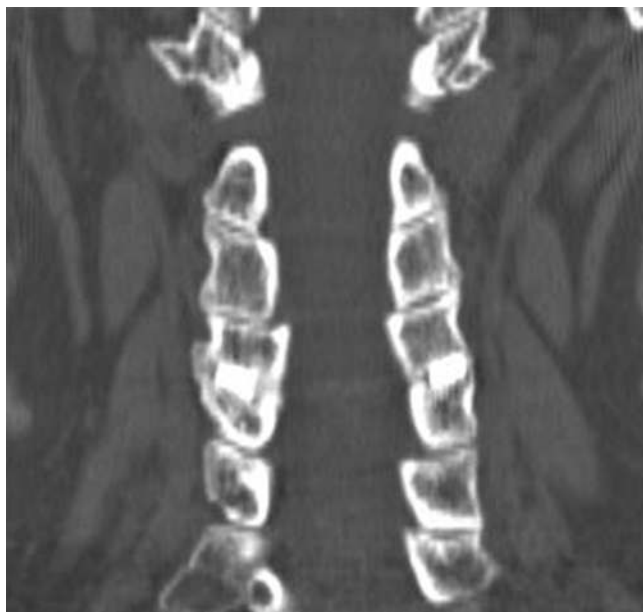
Coronal CT scan of the DTRAX implant at C4–5 showing intrafacet bridging bone.
